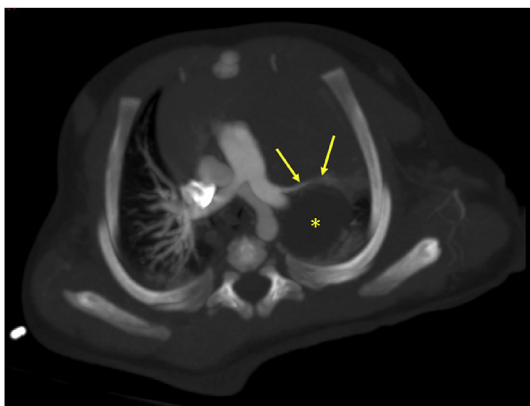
Thoracic CT scan showing the cystic lesion at the left upper hemithorax (asterisk). The cyst is pushing a systemic vessel anteriorly (arrows) which was found intraoperatively to be the feeding vessel of an extralobar pulmonary sequestration.
